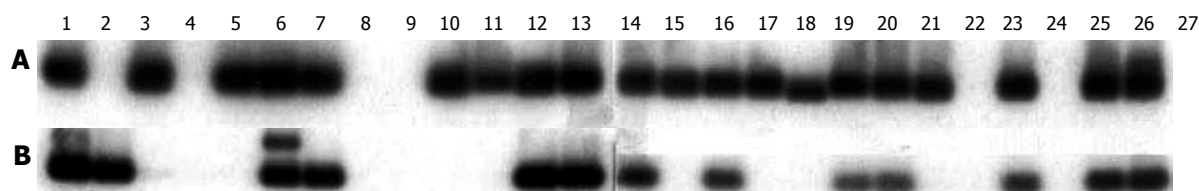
Southern blot hybridization analysis of nested PCR amplicons derived from ss-cDNA 1 to 26 as specified in Table 1. Lane 27 represents a negative PCR control (no ss-cDNA template added to the PCR master mix). Exposure to X-ray films was for 1 d using an intensifier screen at -70 °C. A: hGRP-PCR amplicons; B: hGRP receptor PCR amplicons.
